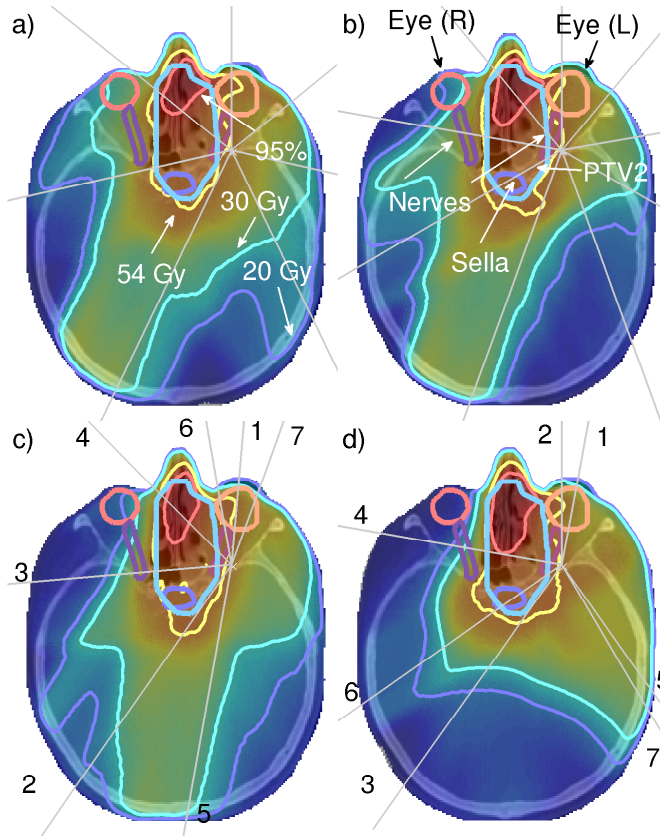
Axial CT-slice of the maxillary sinus case with dose distributions and beams for 4 different beam arrangements: 7 and 9 equi-angular (a) and (b), 7 beam coplanar with optimized beam setup (c) and 7 beams optimized non-coplanar setup (d). In (c) and (d) beam numbers are displayed in the order of selection (see figure 6.4). For the non-coplanar setup, projections of the selected beams on the axial plane are displayed.
